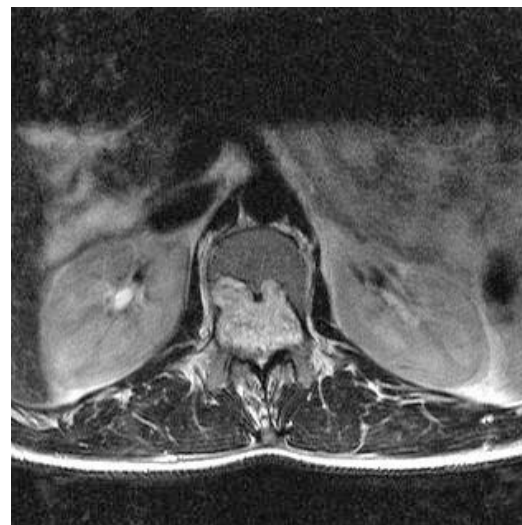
Axial Magnetic Resonance Image Lumbar Spine T2-weighted MRI showing the erosion of the L1 vertebral body
